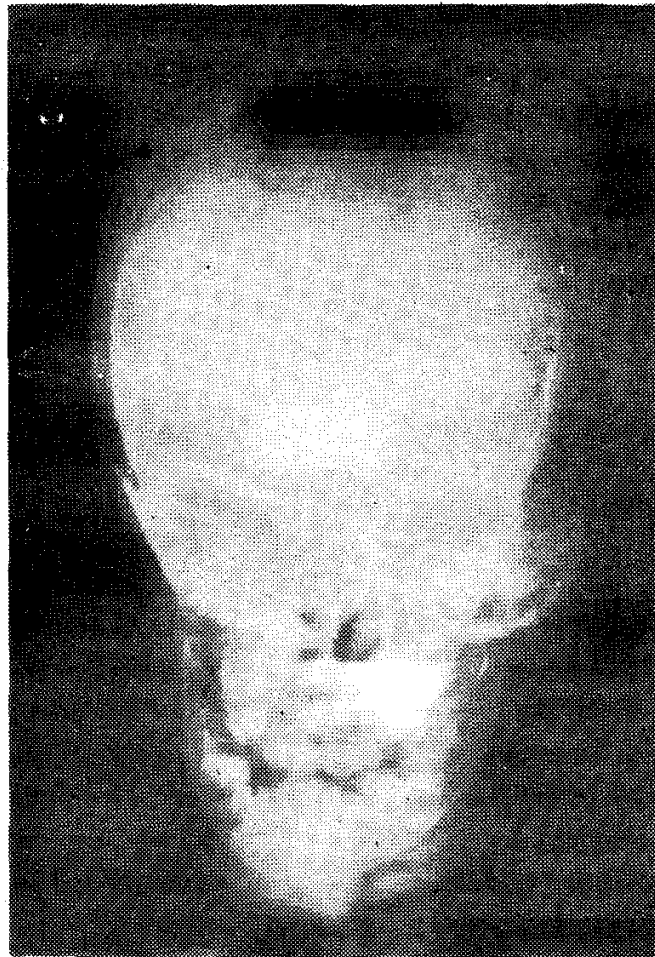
A-P skull radiograph shows a wide open anterior fontanelle and multiple Wormian bones.
